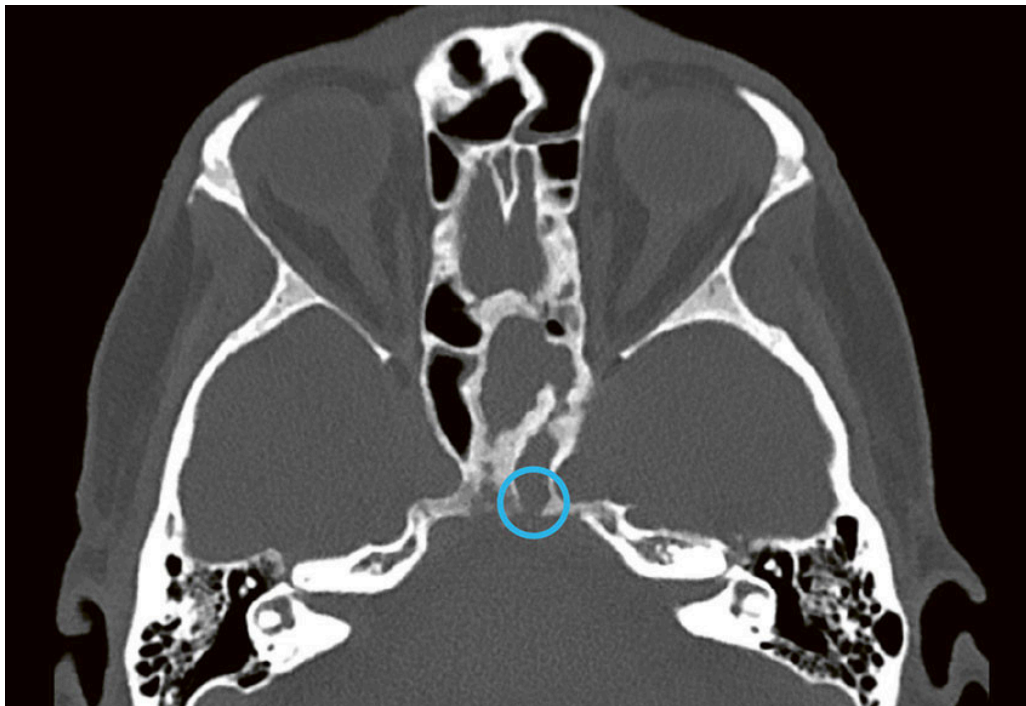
CT of the sinuses showed an opacified, sclerotic left sphenoid sinus consistent with chronic inflammation, accompanied by destruction of the clivus (marked)
